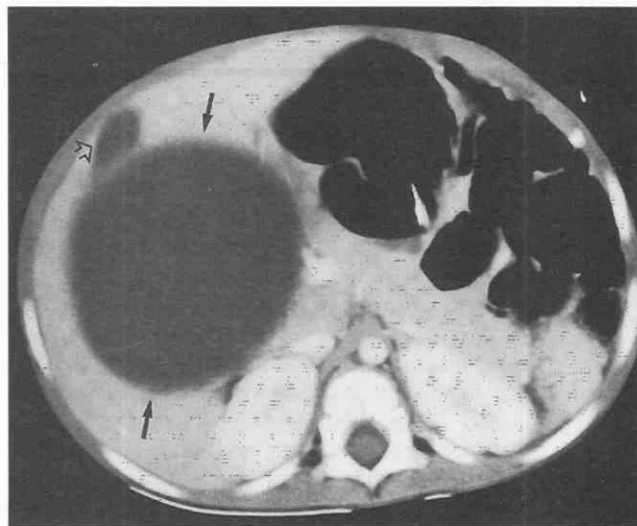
Choledochal cyst. CT of the upper abdomen reveals a large low-attenuation choledochal cyst (arrows) in the portal hilum of the liver. The gallbladder, visualized anteriorly, is displaced by the large choledochal cyst (open arrow).
